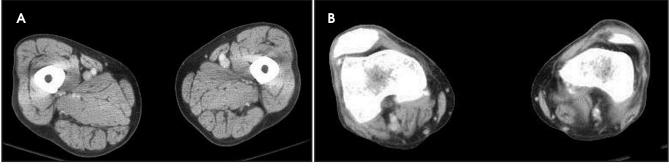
A 79-year-old woman with tachycardia and findings of chronic DVT on CT venography. There was no evidence of pulmonary embolism on CT pulmonary angiography (not shown), nor was there evidence for acute DVT. (A) Transverse CTV image through the mid thighs reveals subtle posterior wall thickening and focal calcification along the left femoral vein. (B) Transverse CTV image through the distal thighs demonstrates a shrunken left popliteal vein.
